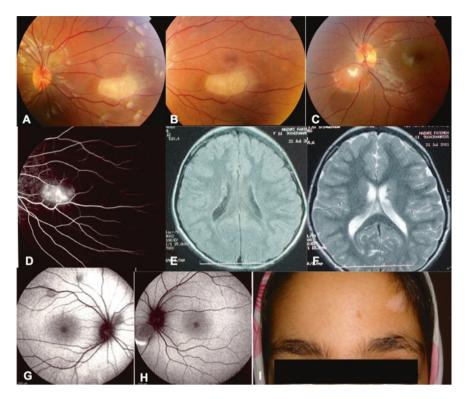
a, b, c Multiple white slate grey and white preretinal lesions in color fundus images. d Fluorescein angiography revealed late leakage . e, f Brain MRI showed multiple brain astrocytoma. g, h Hypo-autofluorescent feature of lesions are remarkable. i The patient had many ash leaf macules on different parts of the body skin
